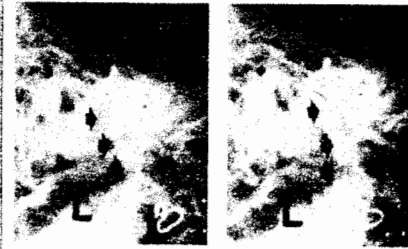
Radiographs of the left mandibular joint with prosthesis in place. Arrows indicate the movement of the condyle neck and stump from the closed to open position.
